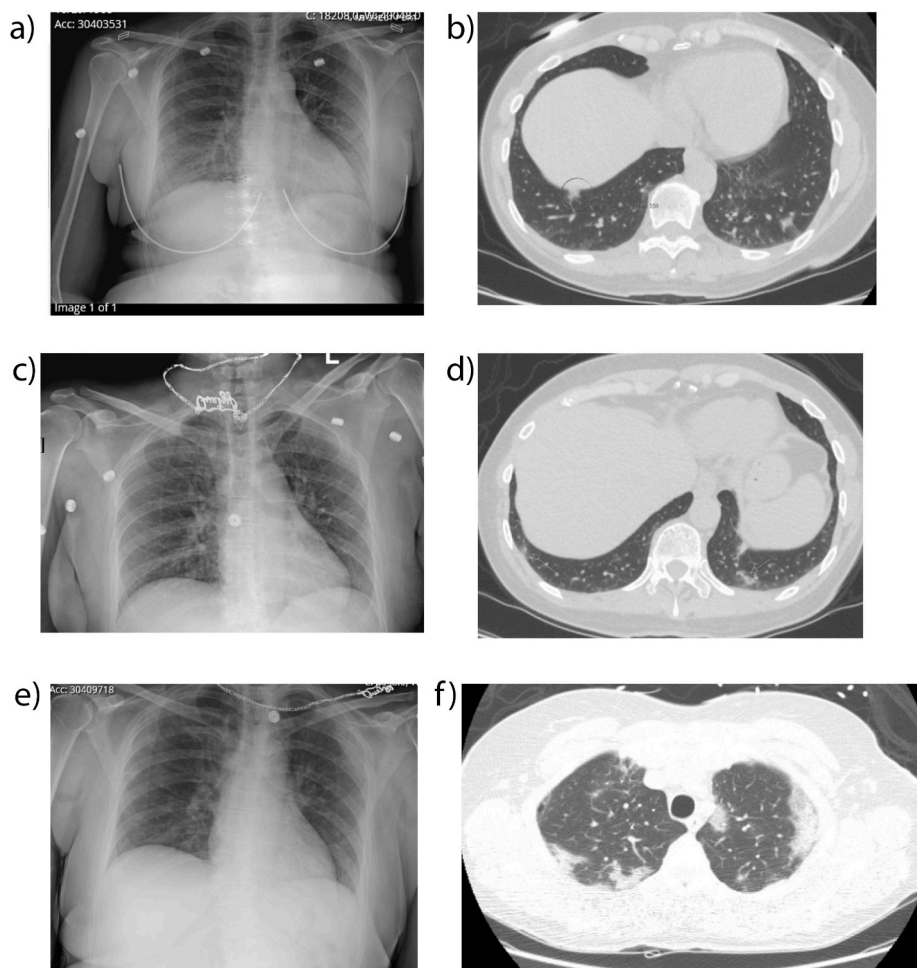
4A, 4B, 4C, 4D (From left to right clockwise): Admission CXR with bibasilar opacities. CT Urogram with images of the lung bases demonstrate peripheral subpleural ground glass nodules as highlighted Fig. 4D: CXR from day of discharge unchanged.
